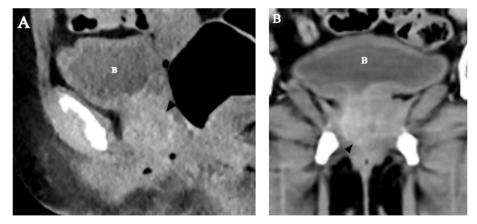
Axial (A) and coronal (B) post-contrast pelvic CT show bulky and predominantly homogeneously enhancing urethral lesion with bladder base extension (arrowhead in A and B).Bladder is labelled B in both images.
